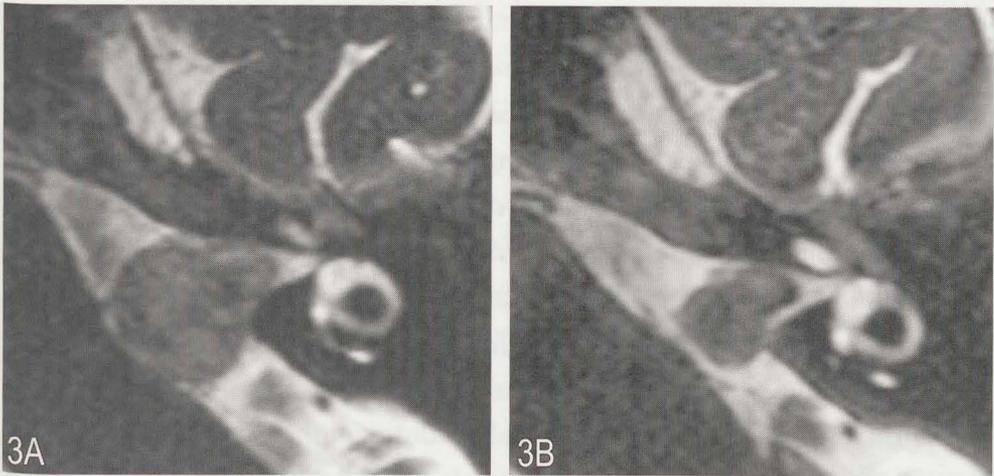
Patient 3. MRI-scans in the axial plane; the images show the largest surface of the tumor, initially (A) and after 4 years follow-up (B). See also Table 3. The images are printed on the same scale.
